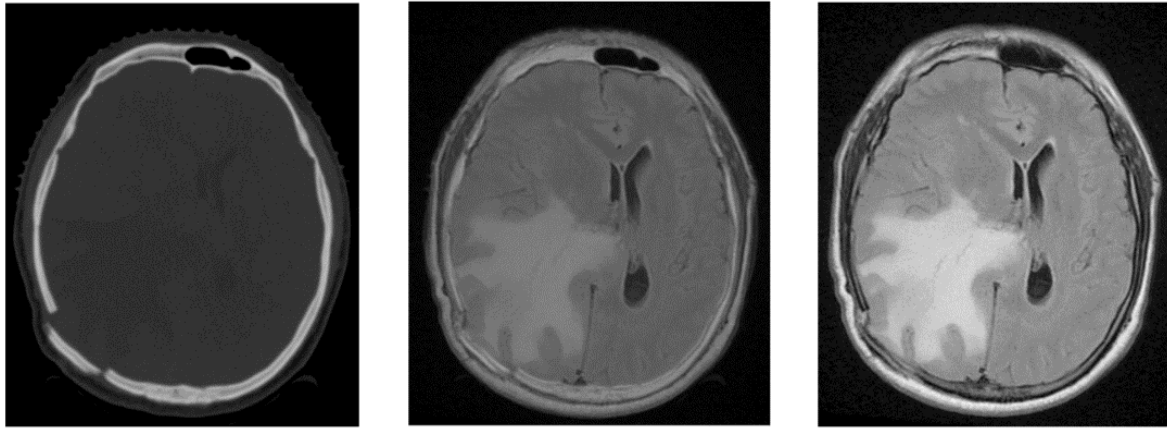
CT image (left), Fused Image (Center), T2 Flair MRI Image (right)
